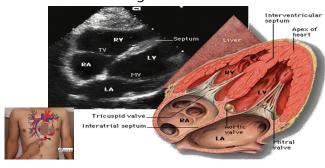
Probe placement and overview of Apical Four Chamber View
